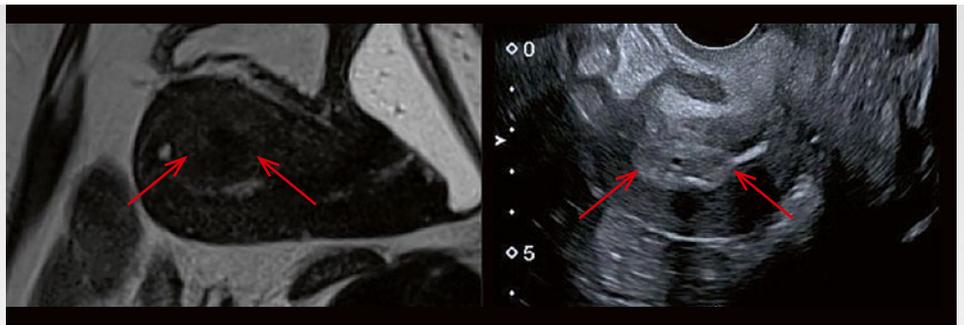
MRI/ultrasound sagittal section: adenomyosis had led to an incorrect endometrium measurement.
